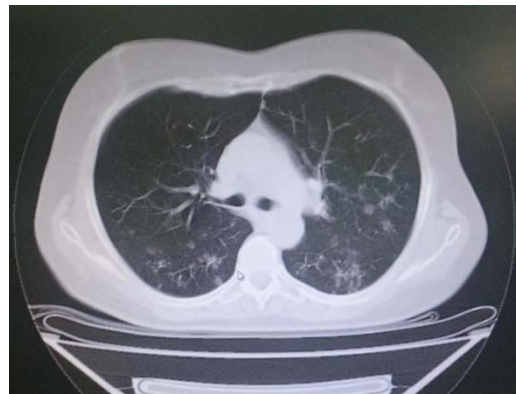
Chest computed tomography (CT) on admission
